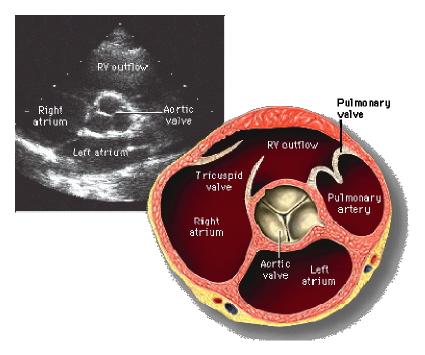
Parasternal short axis
